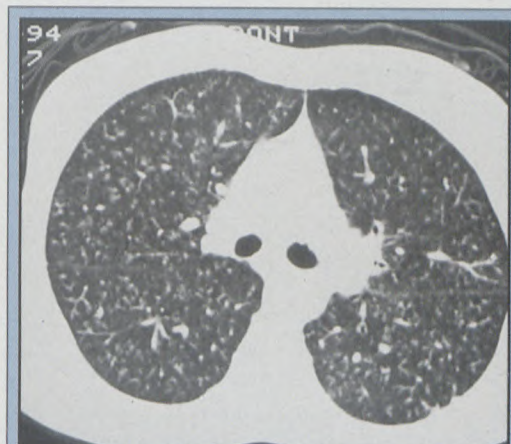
HRCT lung views of the patient shown in 1a confirming the presence of evenly distributed centrilobular nodules in profusion. Fissures are not thickened and bronchovascular markings are normal.
